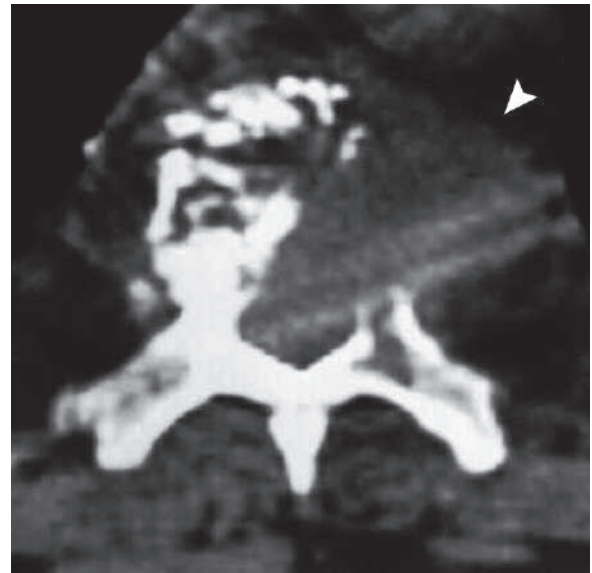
Axial thoracic vertebral CT of a patient with plasmacytoma shows osteolytic soft-tissue mass with external and intraspinal canal extensions (*arrowhead*)
